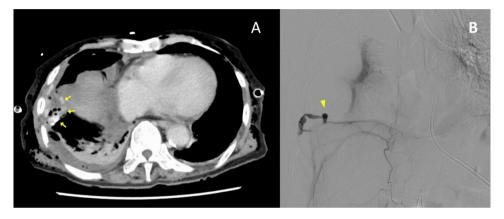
Computed tomography and angiography in Case 3. (A) Computed tomography confirmed a right hemothorax with contrast extravasation into the pleural space. (B) Initial angiography revealed active bleeding from the right inferior phrenic artery
